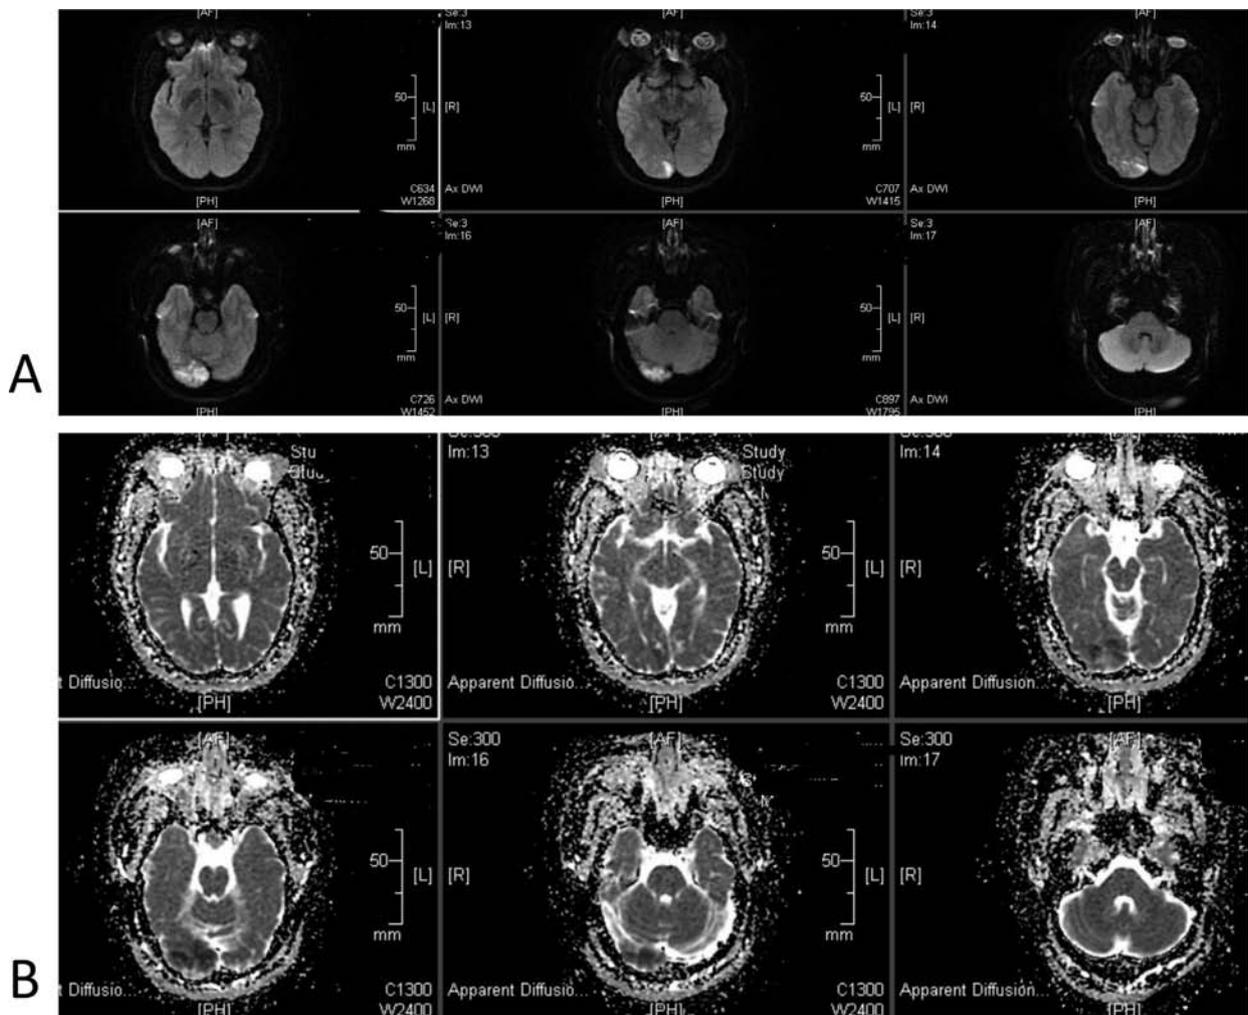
Axial diffusion weighted magnetic resonance images demonstrating restricted diffusion in the right occipital cortex extending into the calcarine fissure (A) corresponding to hypointensity on apparent diffusion coefficient images (B).
